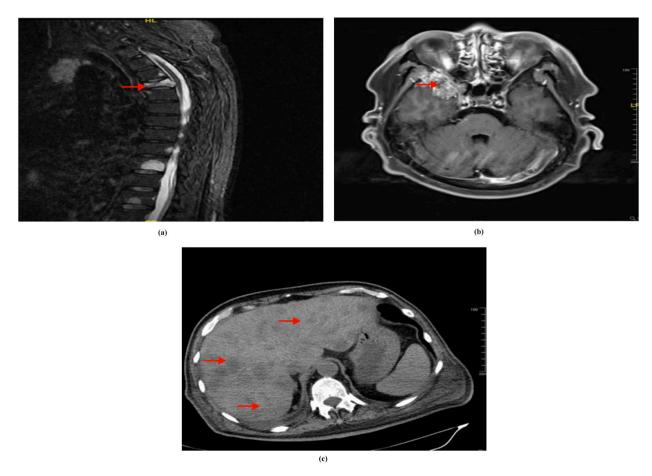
(a)Magnetic Resonance Imaging of metastases and bone fracture of the vertebra; (b) Single metastasis of the right temporal lobe; (c) CT scan of diffuse liver metastases.
